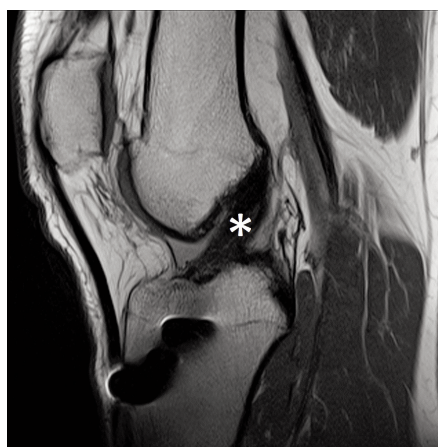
Sagittal proton-density-weighted MRI images with use of slice encoding for metal artefact reduction.¹⁹ Grade 1;²⁰ normal anterior cruciate ligament (ACL) healing, 2 years after a proximal single bundle ACL repair. * = ACL
